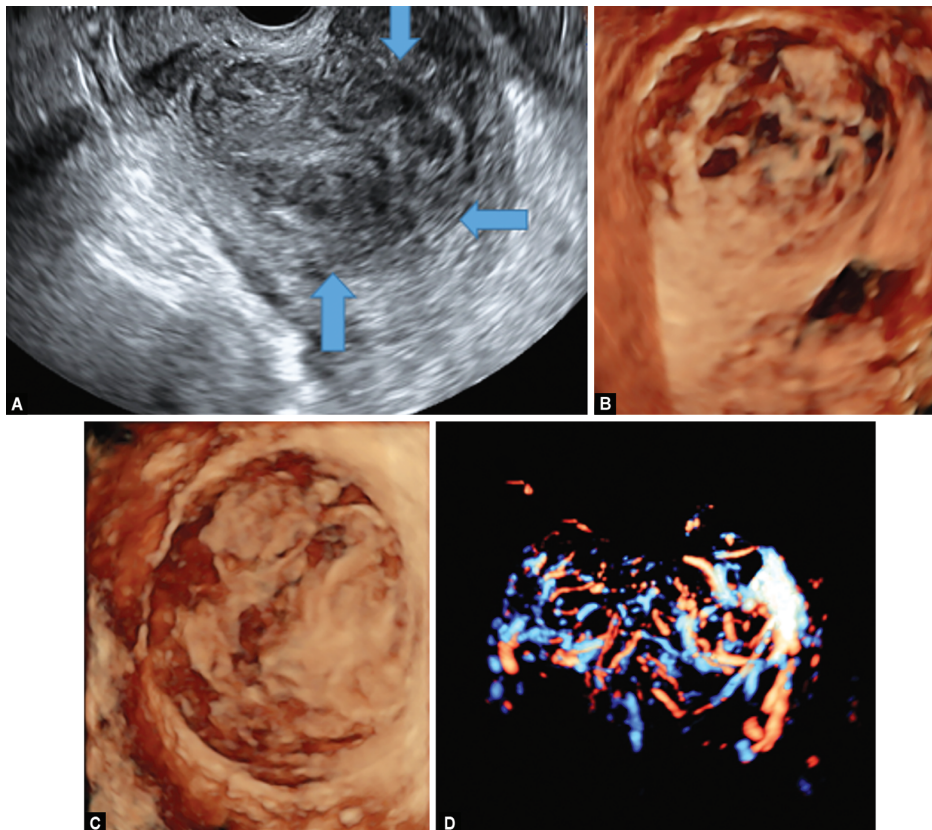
3D ultrasonography of high myoma on fundal region distorting endometrium and serosa (hybrid myoma by FIGO)
